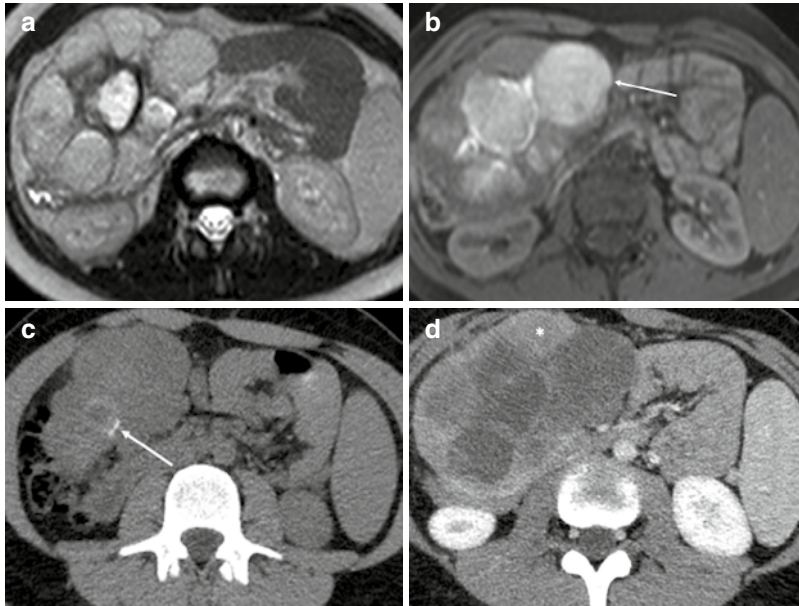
A 14-year-old girl with a solid pseudopapillary tumor in the pancreatic head. (a) T2-weighted image shows a large encapsulated and multilocular mass characterized by cystic portions. (b) On T1-weighted fat-suppressed image, the hemorrhagic component appears
